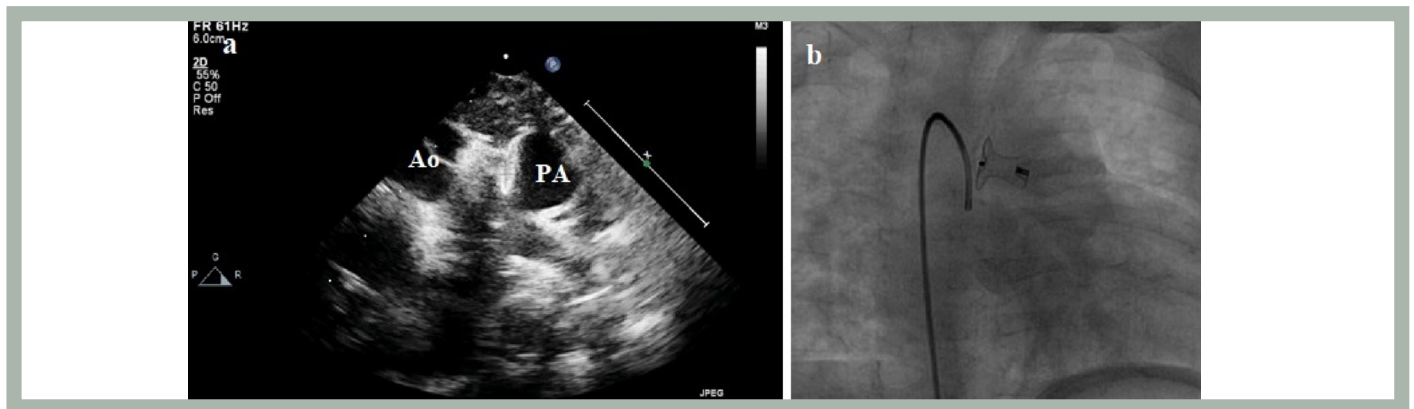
The transthoracic echocardiography (a) and catheter angiography (b) showed a good deployment of the device
